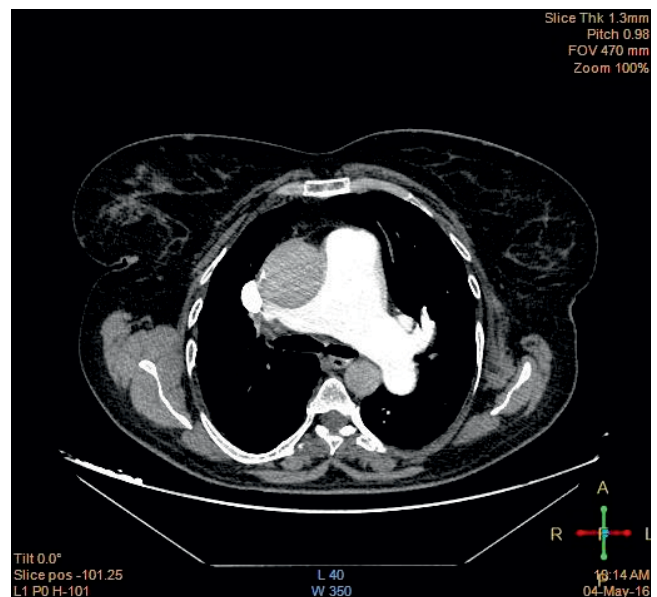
CTA, right superior lobe artery 5 mm, left superior lobe artery 10 mm.
